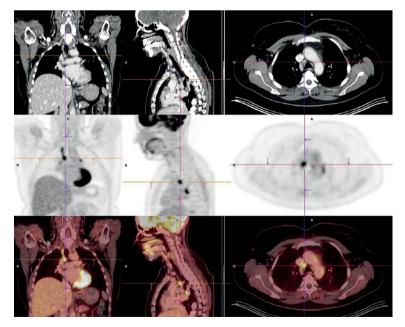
PET-CT patient 3: Suspicious relapse in mediastinal lymph nodes.
